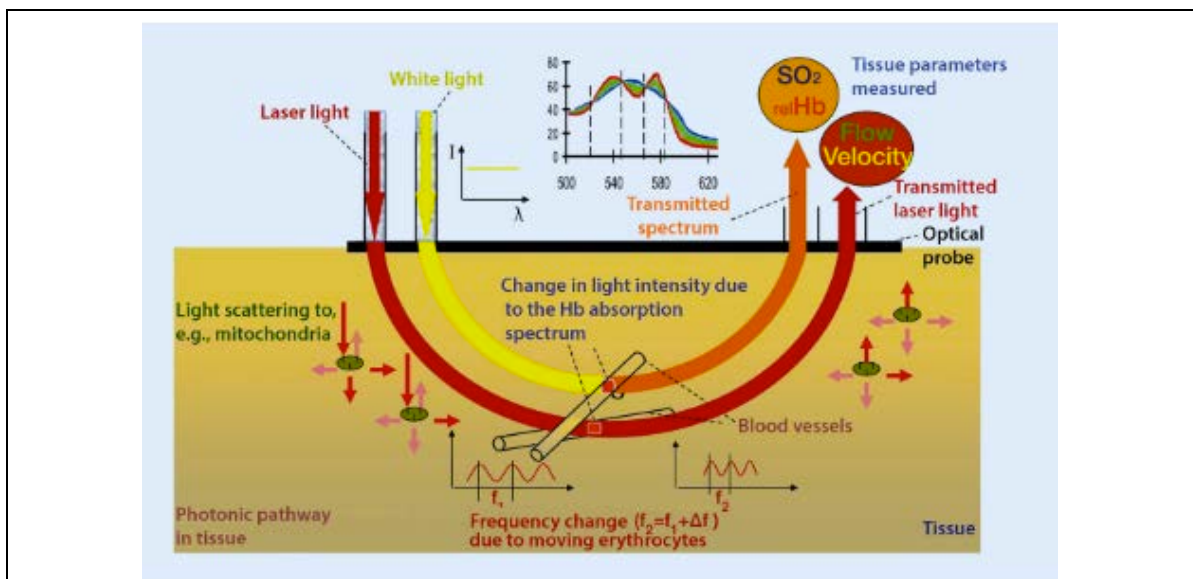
O2C measuring principle is a combination of white light spectrometry and laser Doppler flowmetry (courtesy of LEA Medizintechnik GmbH).
